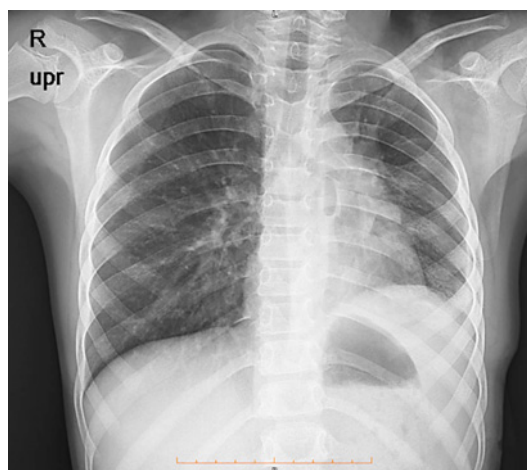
Follow-up chest X-ray after lobectomy treatment.
